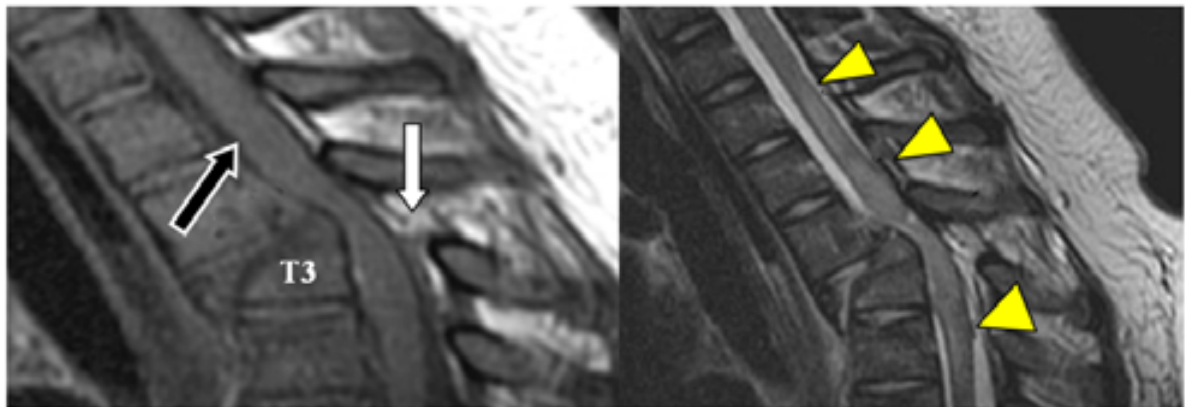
Radiographic images of spinal injuries for driver in Case 3: left, sagittal CT of T3 shows Anterolisthesis fracture (*black arrow*), disruption of ligament (*white arrow*); right, weighted MRI images of upper thoracic spine of T3 shows a compression of spinal cord with cord edema (*arrowheads*)
